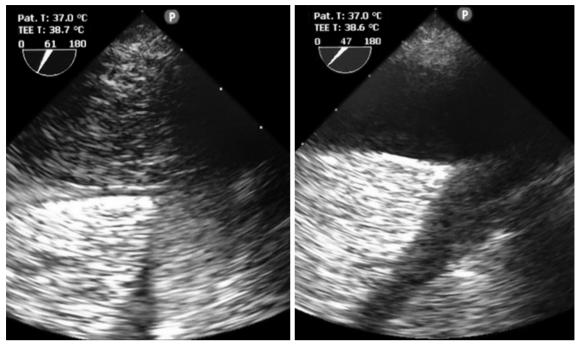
Transesophageal echocardiographic image of a tumor thrombus in inferior vena cava.
